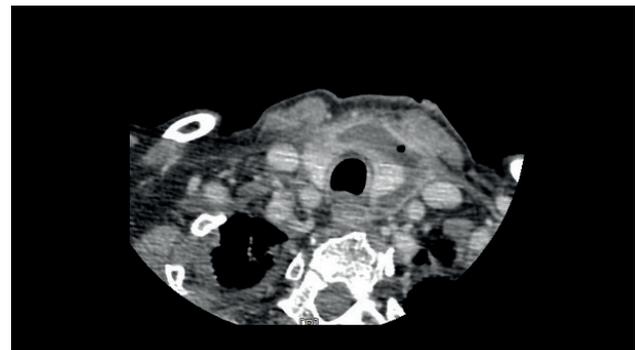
The CT scan of the thorax with contrast showing fluid collections extended anteriorly to trachea till the level of superior mediastinal space.
